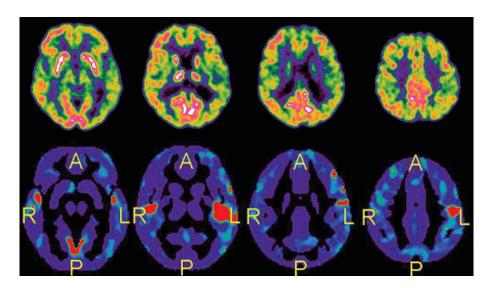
Example of false negative reading with the T-sum score. The AD hypometabolic pattern was recognized by the expert while the PALZ score was not significantly increased in a 72 year-old man converted to AD-dementia after 40 months of follow-up. On top, FDG-PET visual analysis discloses moderately reduced uptake in left temporo-parietal cortex while the statistical PMOD maps (on bottom) shows significant hypometabolic clusters in bilateral temporal regions and left parietal cortex without reaching the statistical threshold (T-sum = 7,225). Other details as in Fig. 1.
